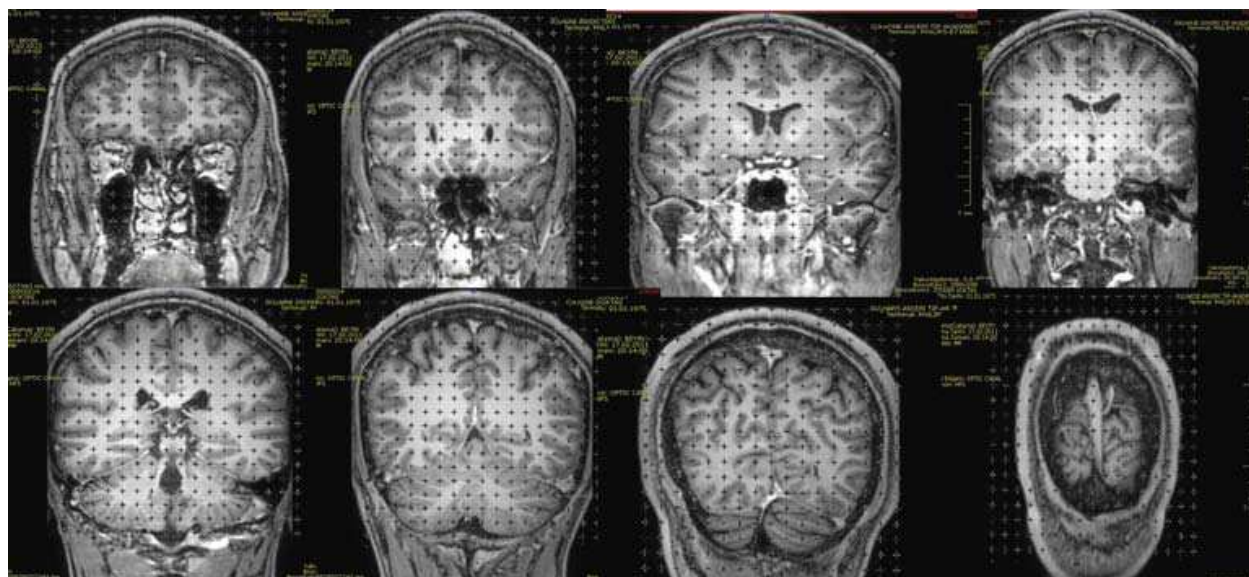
Acoronal MRI series with a point-counting on it for the estimation of the cerebral volume from first to last section ($T=1.6$ cm)
